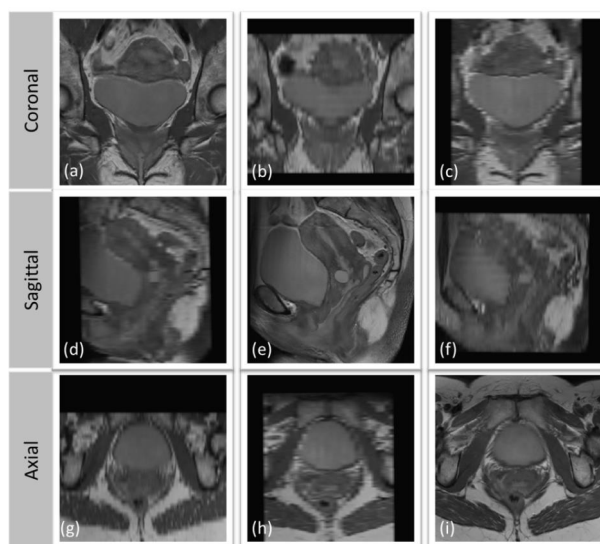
Three-view pelvic MR images. (a), (e), and (i) are the scanned high-resolution coronal, sagittal, and axial images, respectively. (d) and (g) are low-resolution projected from (a), (b) and (h) are projected from (e), and (c) and (f) are projected from (i).
